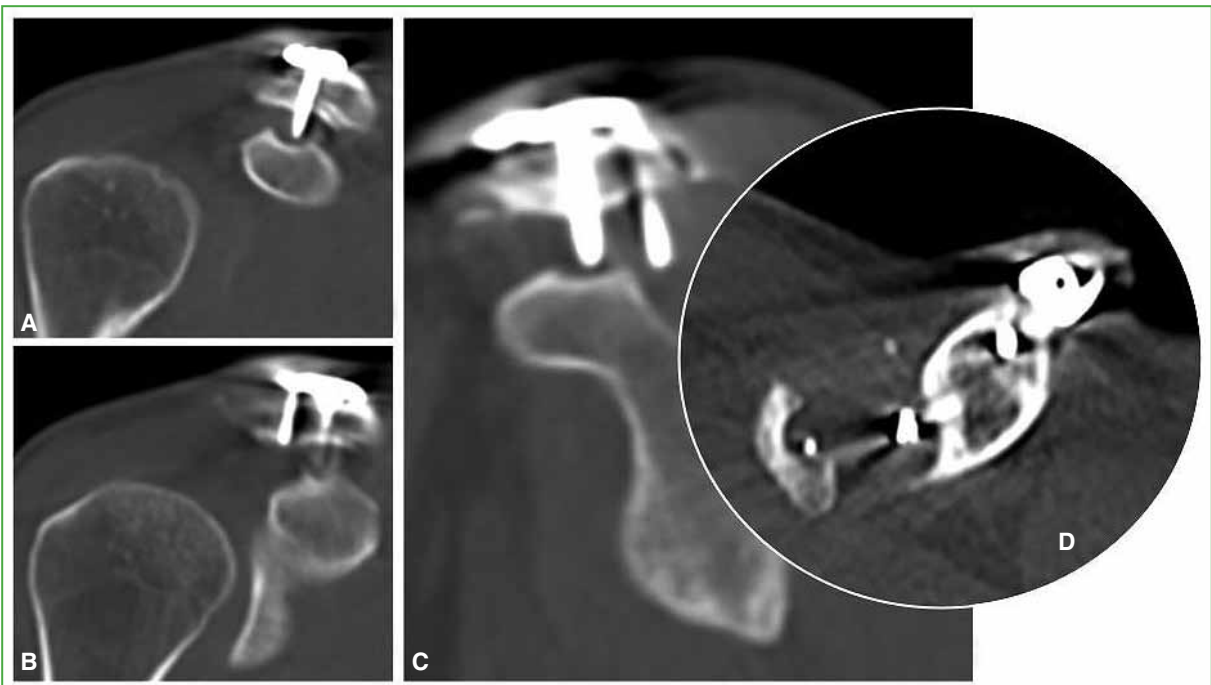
Preoperative 3D computed tomography of the right shoulder. A and B. Coronal sections. C. Sagittal section. D. Axial section showing >50% involvement of the coracoid process surface.
